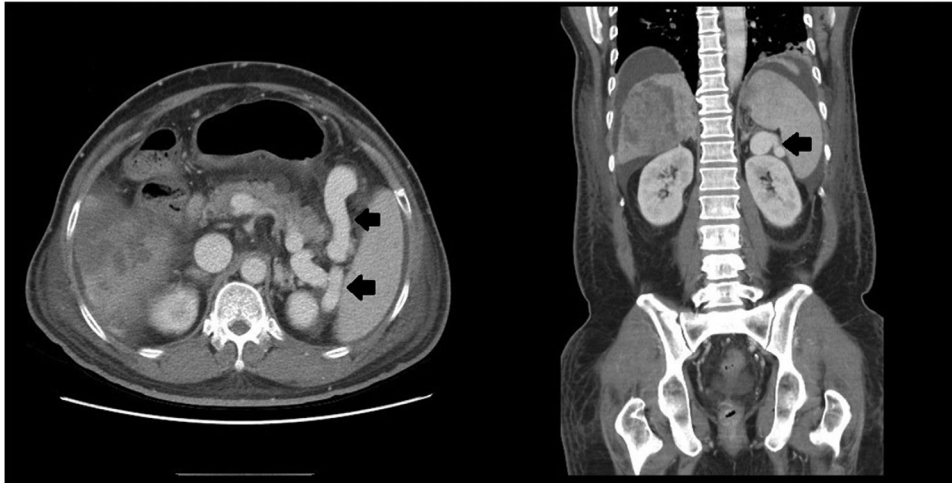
Computed tomography of the abdomen at the arterial phase showed typical lienorenal varices located in the lienorenal ligament between the spleen and left kidney (arrows)
